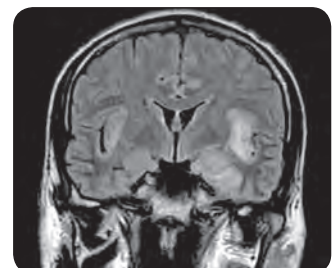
T2-weighted (FLAIR) coronal image of herpes simplex virus encephalitis affecting temporal lobes
